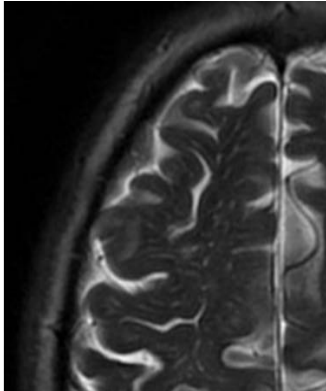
Axial T2-weighted images slices demonstrating varying numbers of EPVS at different levels of centrum semiovale, with fewer EPVS visible closer to the vertex (right image)
